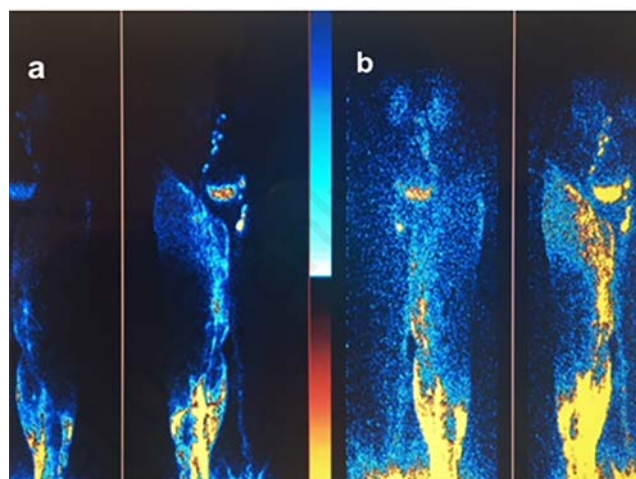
Lymphoscintigram showing relocation of tissue (edema) fluid after IPC therapy for 3 months. A) before therapy - accumulation of tracer in the calf reaching inguinal crease (posterior-anterior view); B) after therapy tracer moved to the thigh and gluteal region. Evidence for effectiveness of IPC method.
